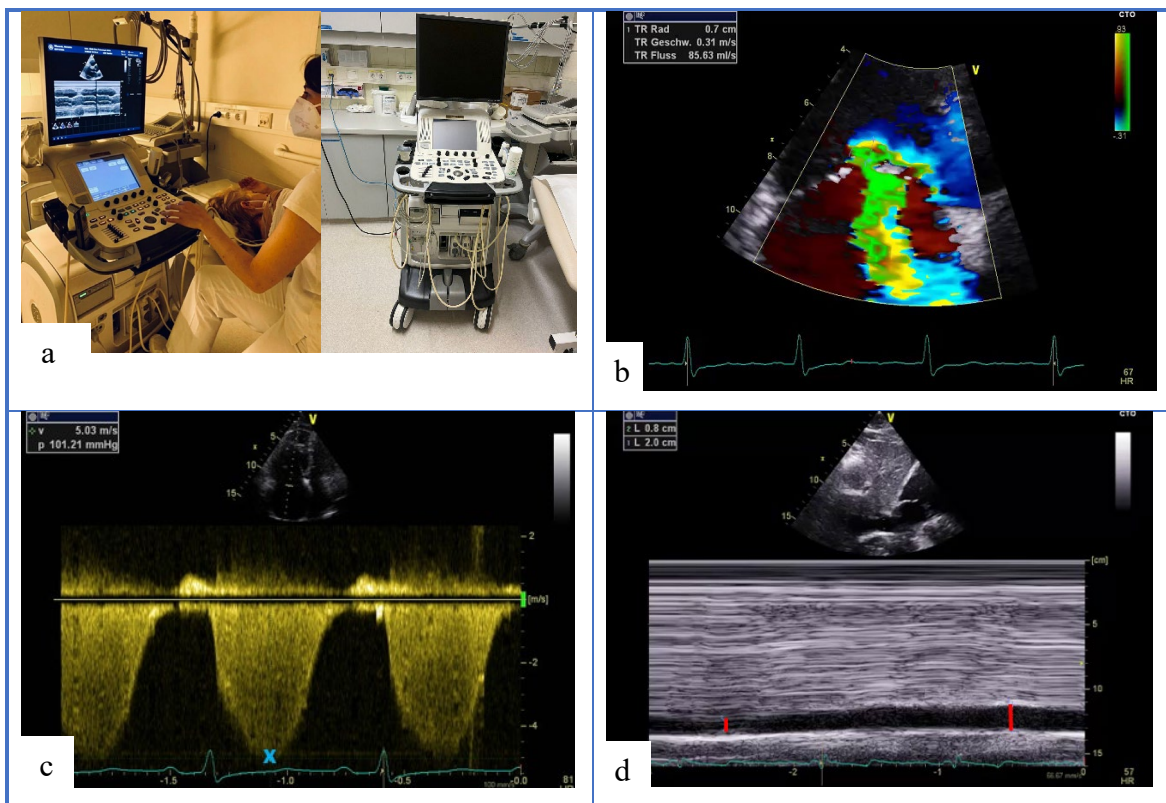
Vivid E9 Ultrasound device, GE healthcare (a), determination of sPAP (b-d)
